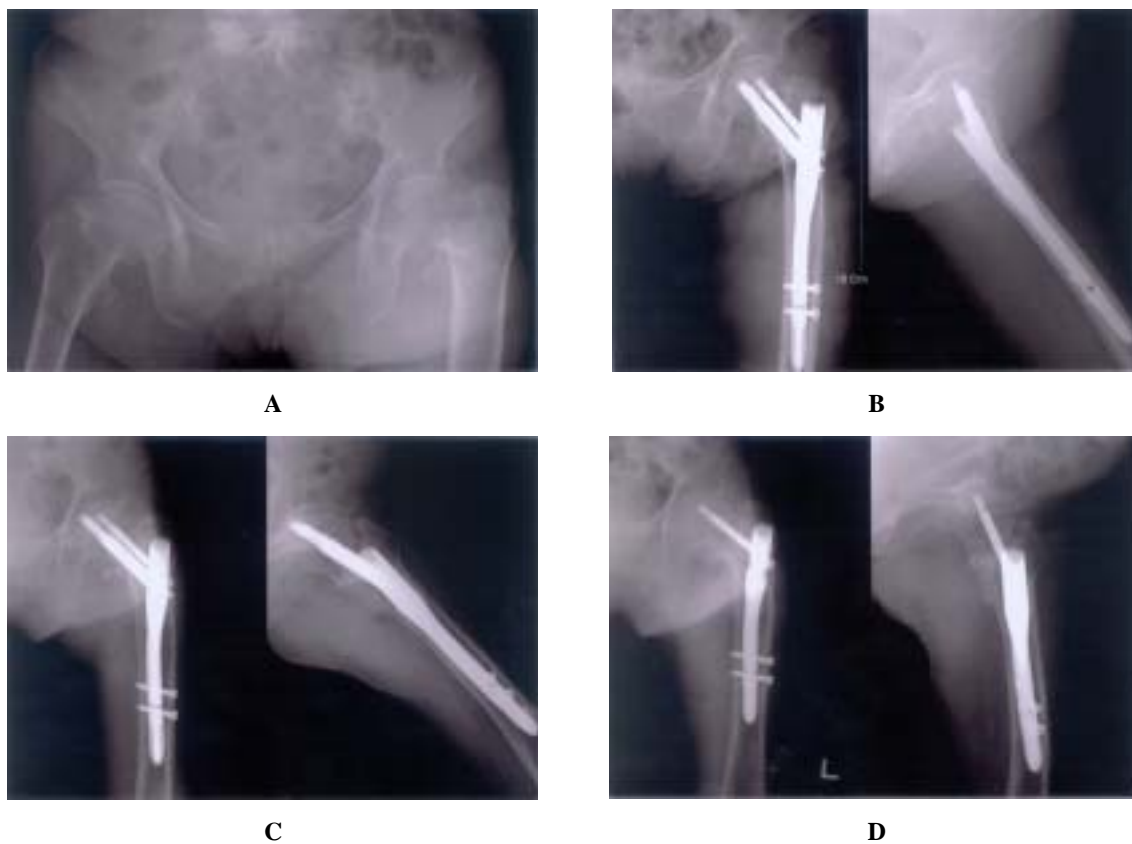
Initial radiographs in a 76-year old woman showing unstable intertrochanteric femoral 31-A2 type fracture.
